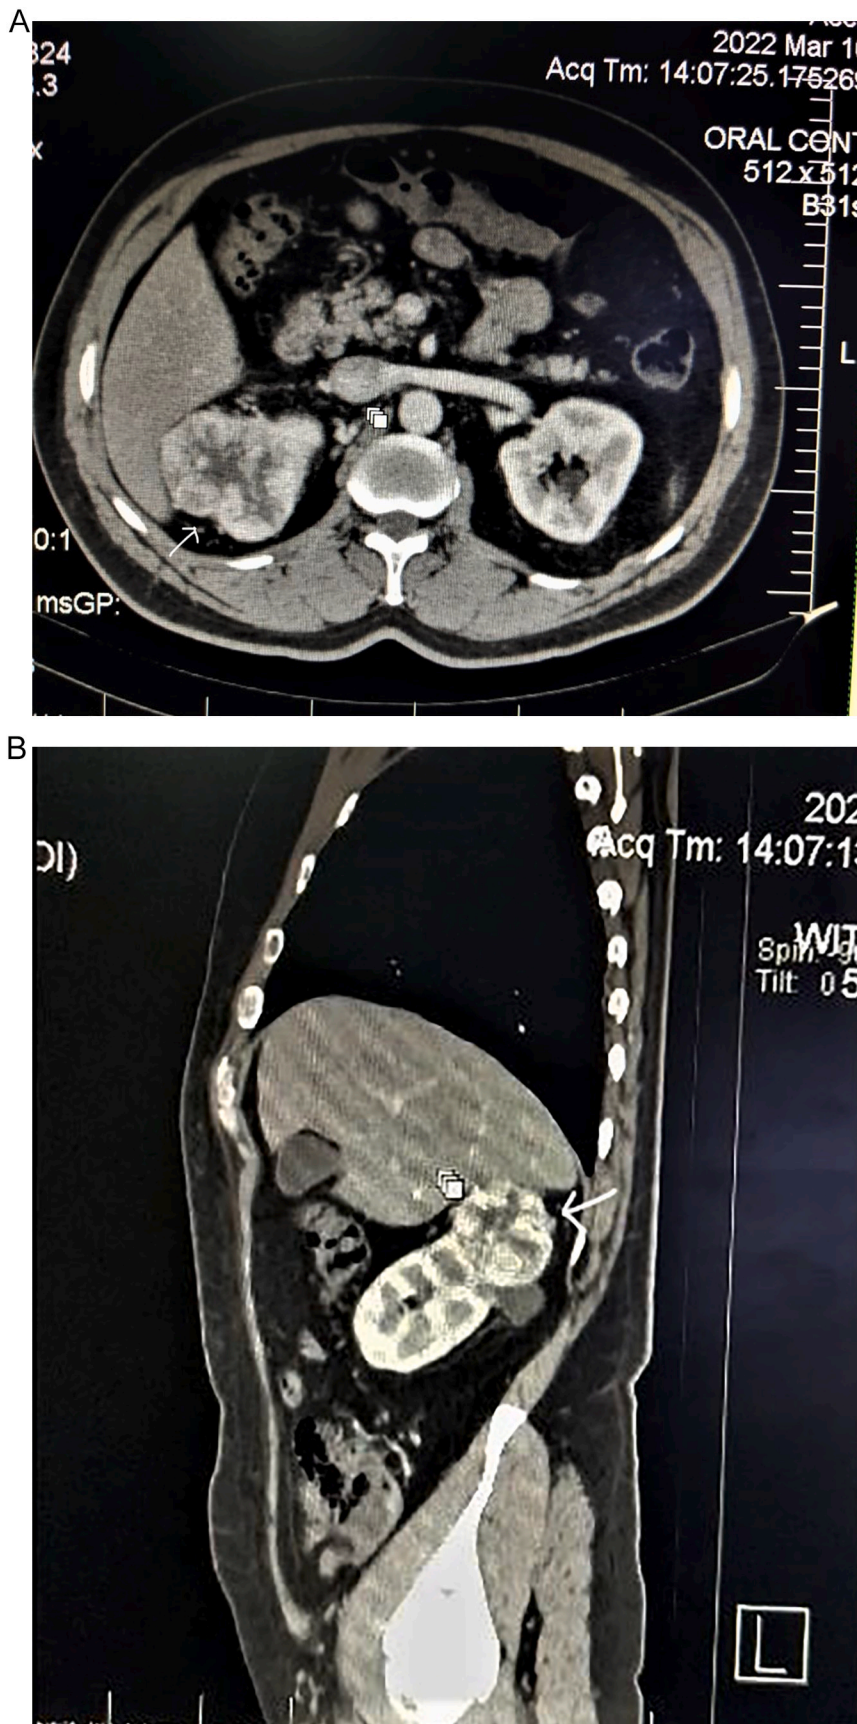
(A-B): Preoperative CT scan cross sectional and sagittal views respectively, revealed a radiant mass in the superior pole of the right kidney was noted and measured (6 × 7 cm). This is clarified by the (Arrow).
